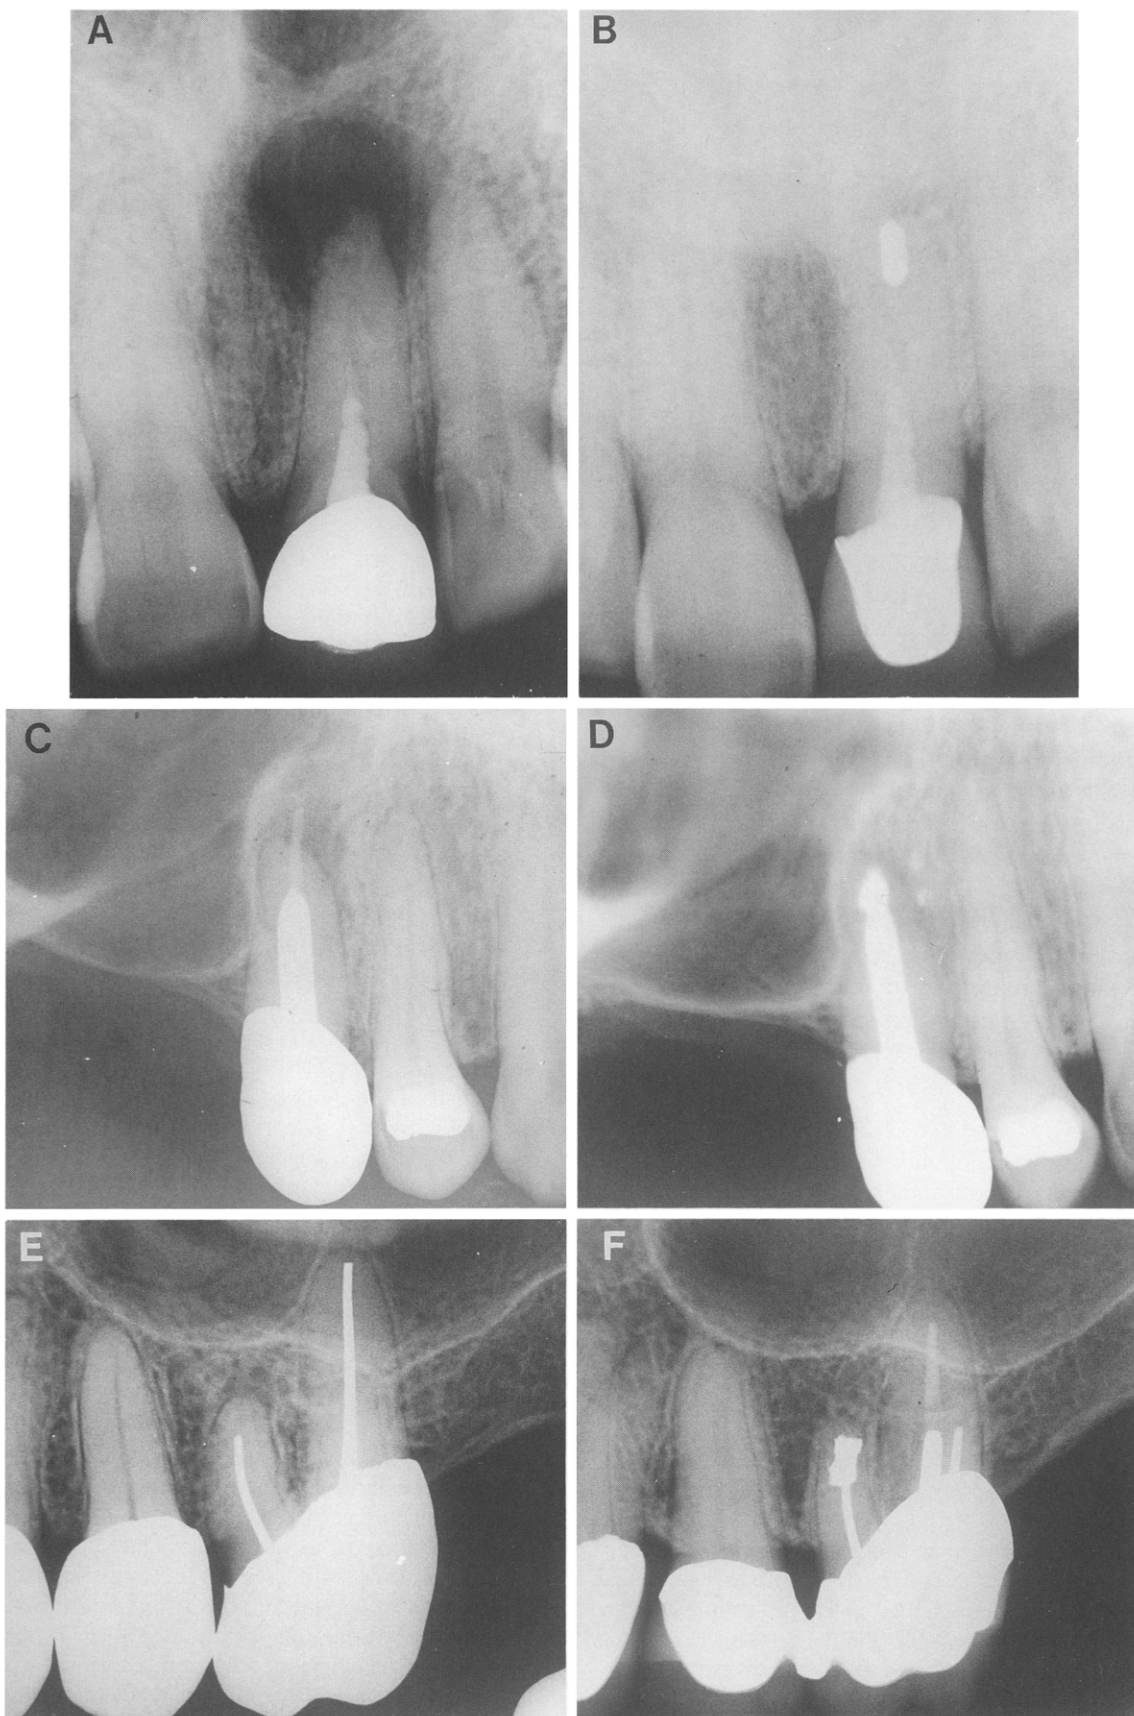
Typical successful cases. *A*, Preoperative film of maxillary central incisor, large periapical lesion, and partial paste filling. *B*, View 16 yr later with complete healing following apical curettage and placement of apical amalgam. *C*, Preoperative view of maxillary second premolar, overextended gutta-percha filling, periapical radiolucency, and apical tenderness. Large post would make removal hazardous for nonsurgical retreatment. *D*, Film taken 12 yr later with excellent healing following curettage and apically placed amalgam. Note, amalgam seems to be in direct contact with metal post. *E*, Preoperative radiograph of maxillary first molar, periapical lesion associated with mesiobuccal root and apical tenderness. *F*, Film taken 18 yr later. At time of surgery, 2 MB canals were located, so figure eight-type preparation was utilized for placement of apical amalgam and excellent healing is seen. A new crown is now present, and the palatal canal was retreated with gutta-percha as filling material in order to provide for a post.
